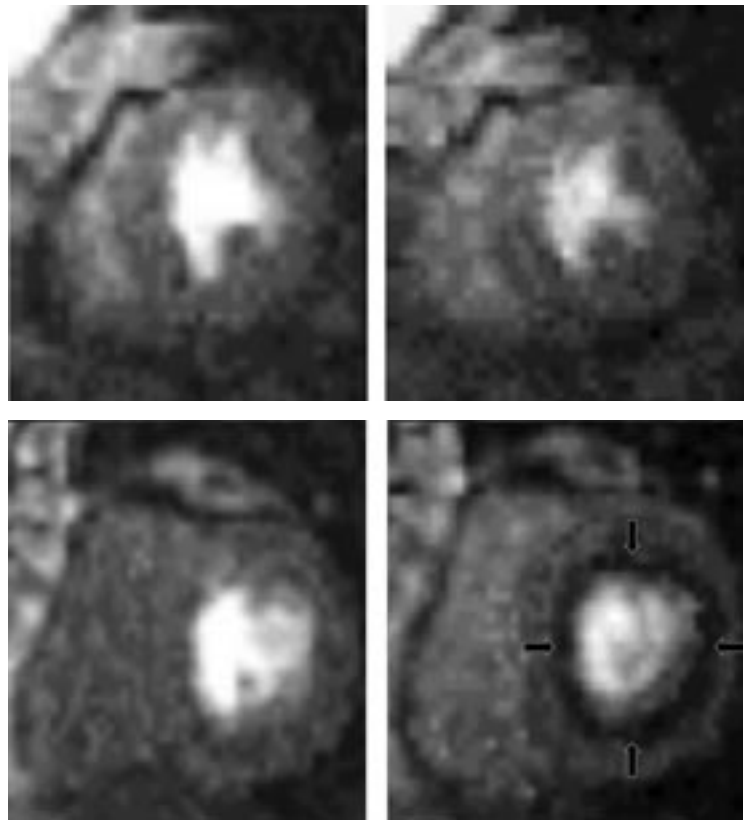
Top, cardiovascular magnetic resonance imaging in a control subject at rest (left) and during stress (right). Bottom, images in a patient with syndrome X at rest (left) and during stress (right)
